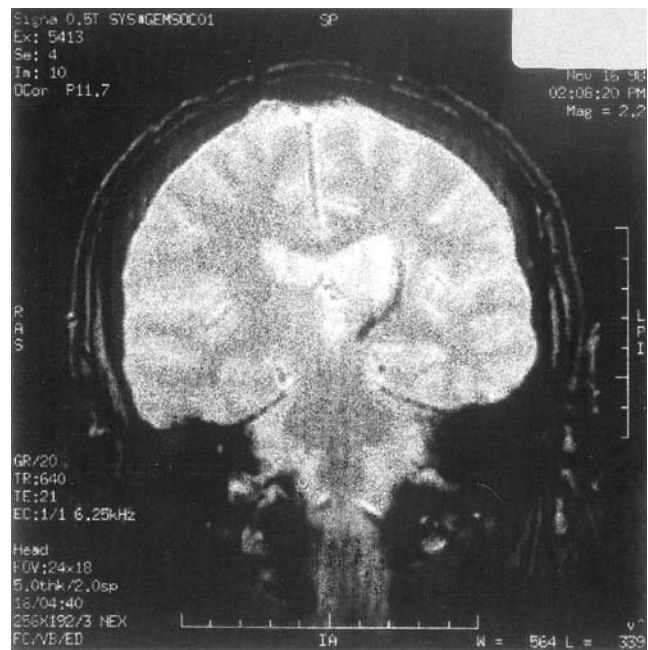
Coronal MRI scan performed two and a half years after stroke showing the sequelae of the lesion (hemosiderin laden scar) encroaching upon the left thalamus. Left side of the brain shown on the right side of the figure
